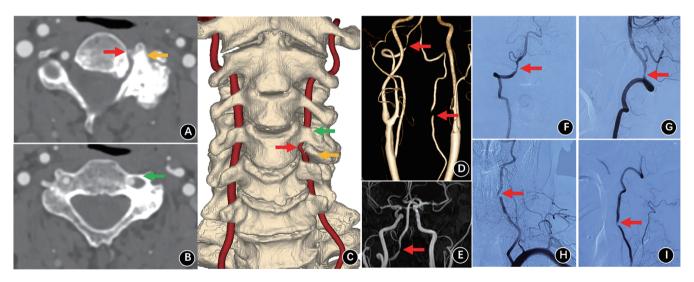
(A–C) preoperative axial CT scan and 3D reconstruction images of the left C4/5 facet joint originated osteophyte (yellow arrow) compressing the left vertebral artery (VA) (red arrow) and intact anterior margin of the left C4 transverse foramen relative to postoperative CT images (green arrow). (D) preoperative CTA showing severe stenosis of the V2 segment of the left VA (red arrow) and the V4 segment of the right VA (red arrow). (E) preoperative MRA showing poor blood flow of the V4 segment of the left VA and stenosis of the V4 segment of the right VA (red arrow). (F, G) acceptable atherosclerotic stenosis of the V4 segment of the right VA (red arrow). (H, I) preoperative DSA showing 95% occlusion of the V2 segment of the left VA (red arrow).
